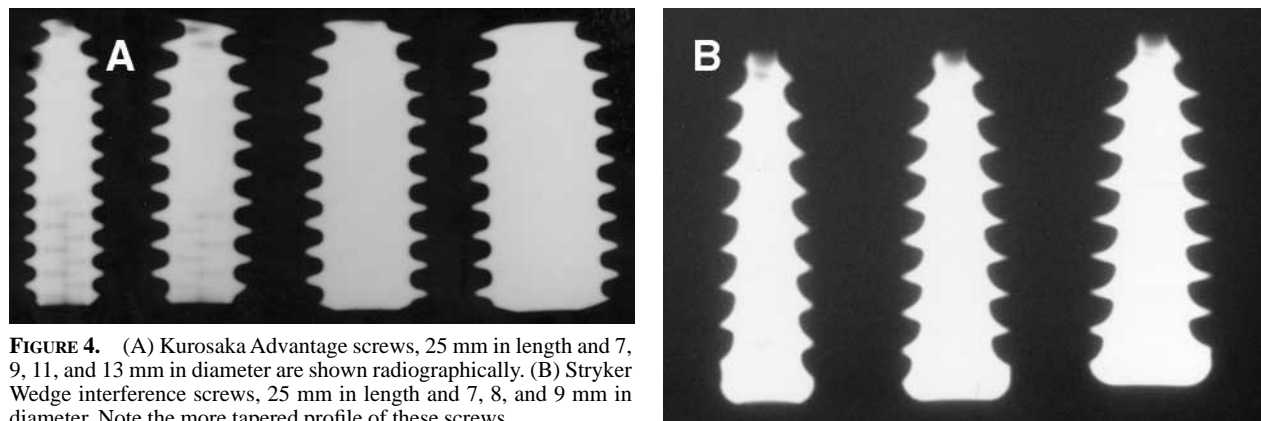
(A) Kurosaka Advantage screws, 25 mm in length and 7, 9, 11, and 13 mm in diameter are shown radiographically. (B) Stryker Wedge interference screws, 25 mm in length and 7, 8, and 9 mm in diameter. Note the more tapered profile of these screws.
